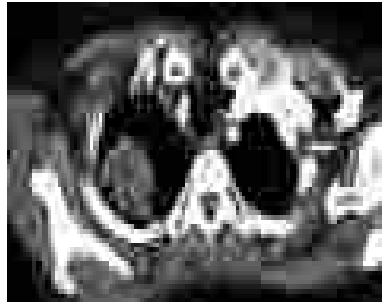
Computed tomography. Lung apex cancer on the right*
